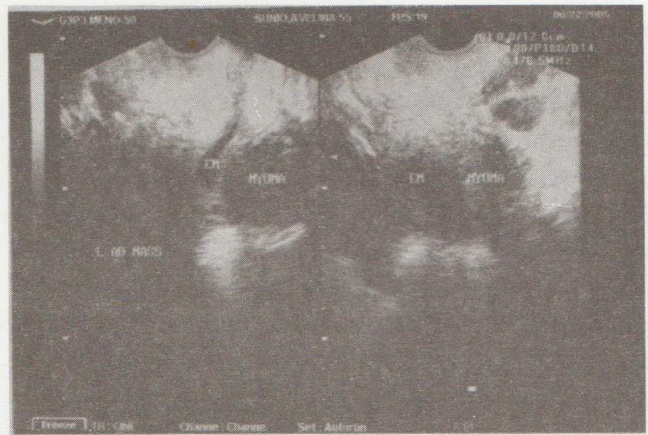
Vaginal sonography showing two well-circumscribed heterogeneous uterine masses: (M1) 3.8 cm x 3.3 cm x 3.0 cm, located at the anterior midcorpus, subserous, and (M2) 0.5 cm x 0.5 cm x 0.5 cm, located at the anterior isthmus, intramural.
